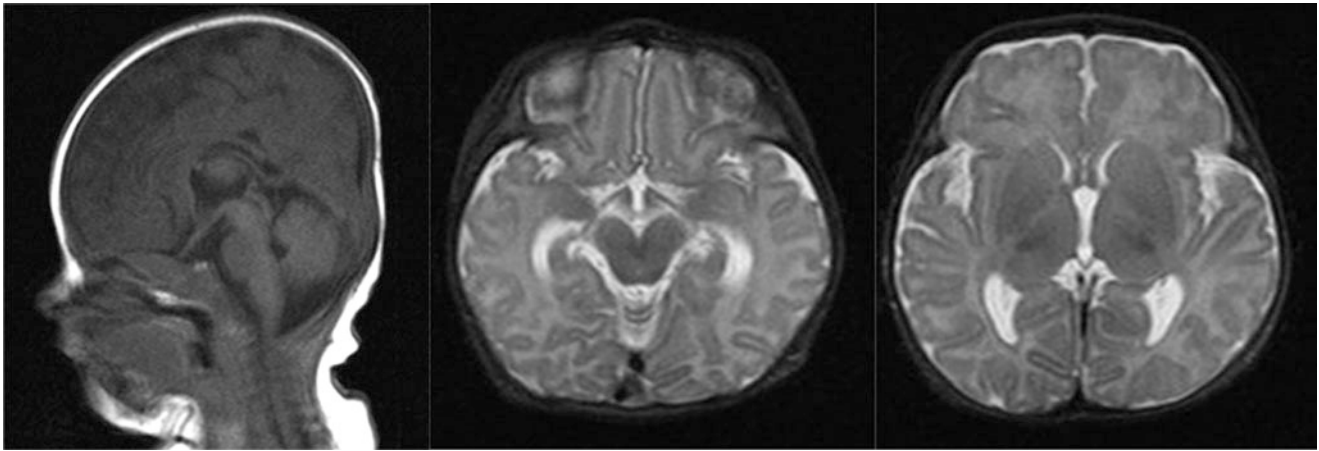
Initial MRI performed at 4 weeks of age
